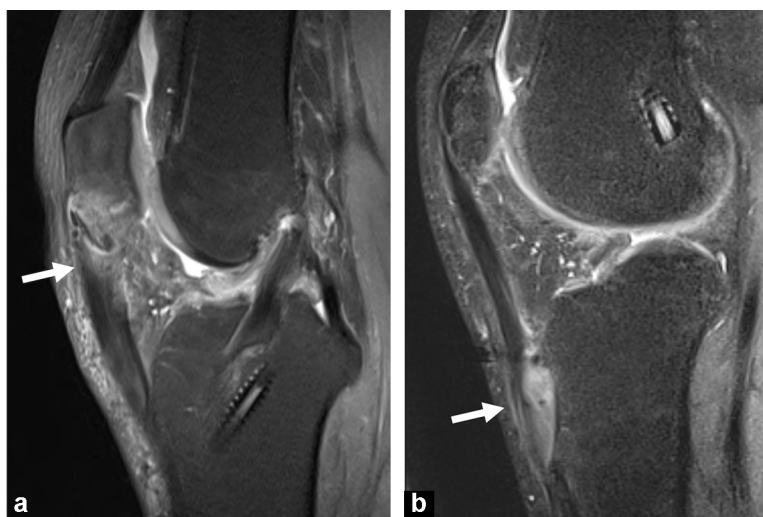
a and b: patellar tendinopathy after BTB reconstruction in 2 different patients. Sagittal on fat-suppressed PD-weighted MR images.
